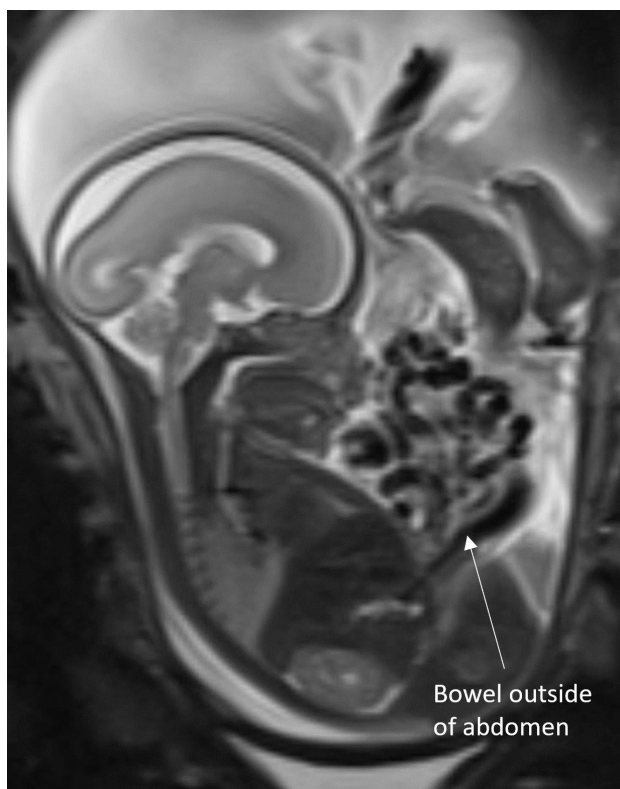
T2 HASTE STIR Sagittal MRI image of gastroschisis in 25 week fetus
